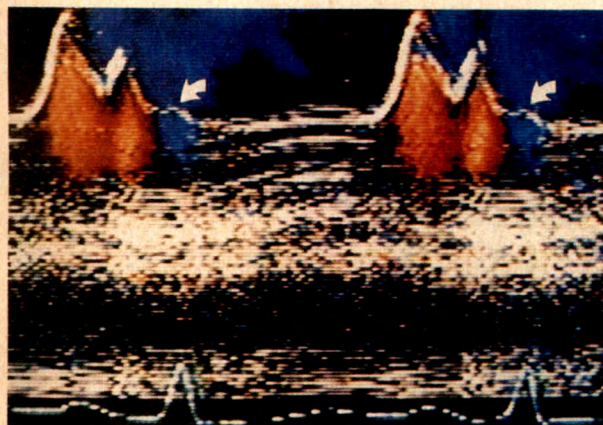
M-mode color Doppler echocardiographic detection of mitral regurgitation (white arrows) coincident with the B bump of the mitral valve. Mitral regurgitation is demonstrated as blue signals (white arrows) behind the mitral valve that coincide with the B bump.
